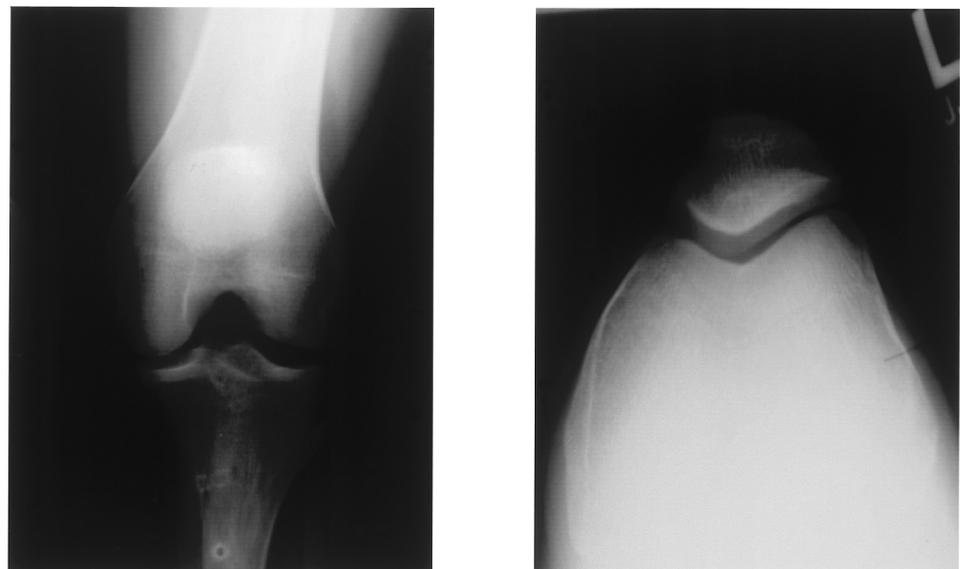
Preoperative AP and lateral radiographs. Note normal bony alignment and no evidence of significant patellar lateralization.
